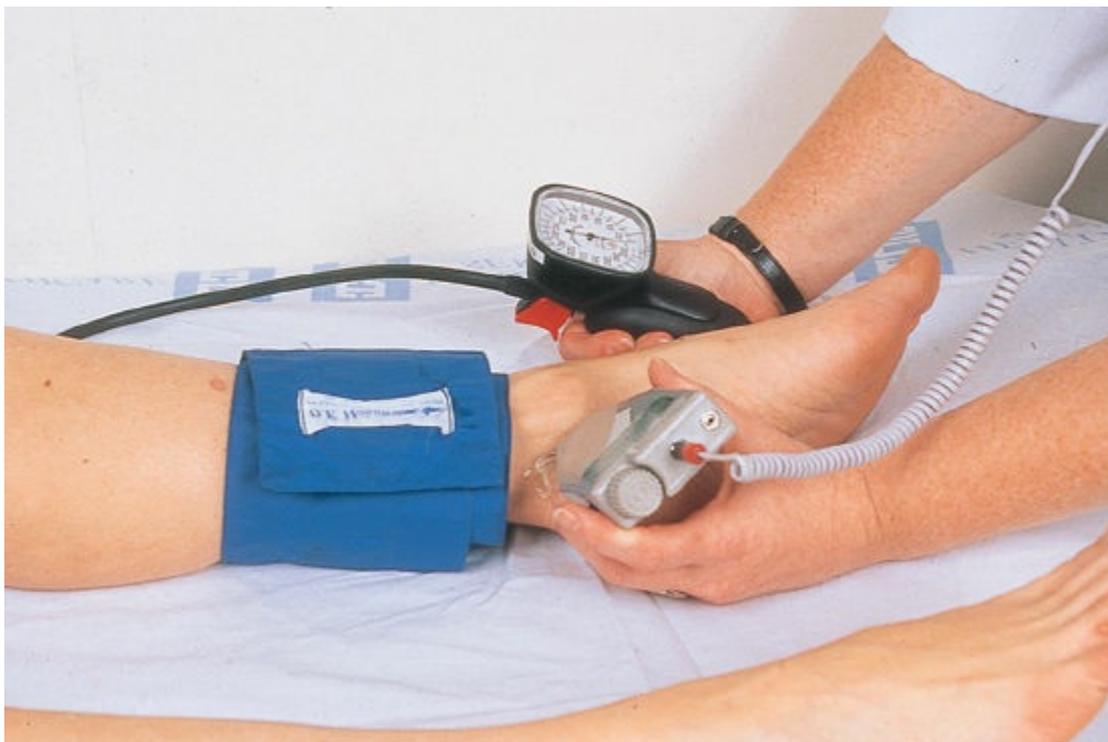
Continuous-wave (CW) Doppler ultrasound detects blood flow in peripheral vessels (demonstrated in obtaining ABI).
